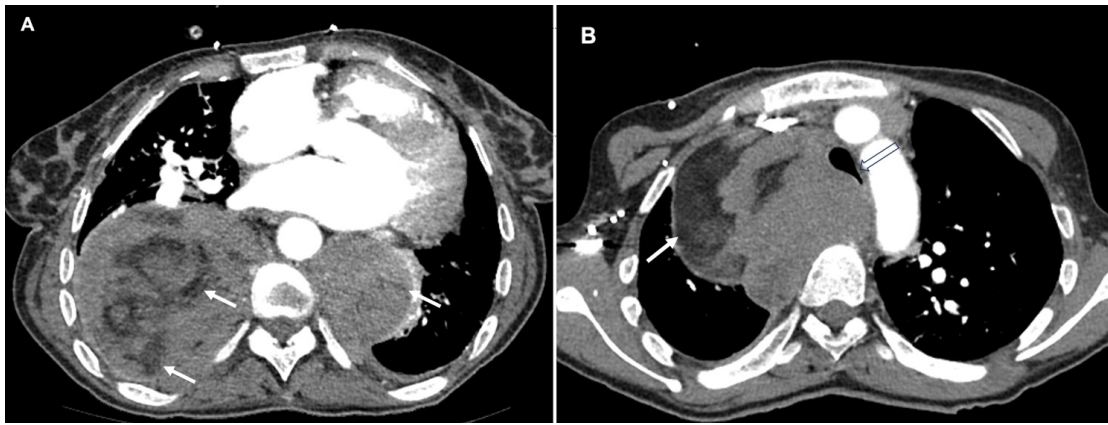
(A, B) Axial contrast-enhanced chest computed tomography images show well-defined giant masses in the mediastinum with areas of macroscopic fat densities (filled arrows). Note the tracheal compression and narrowing due to the right paravertebral mass (hollow arrow).
